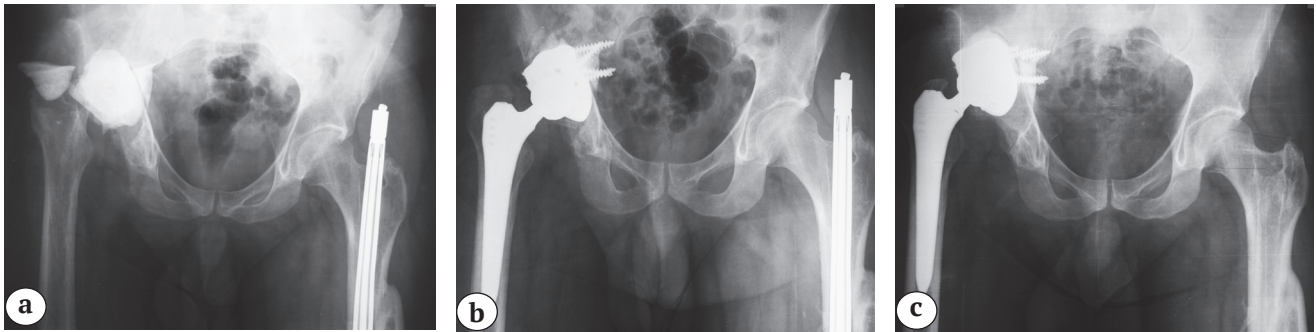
X-rays of male patient 27 y.o.:
